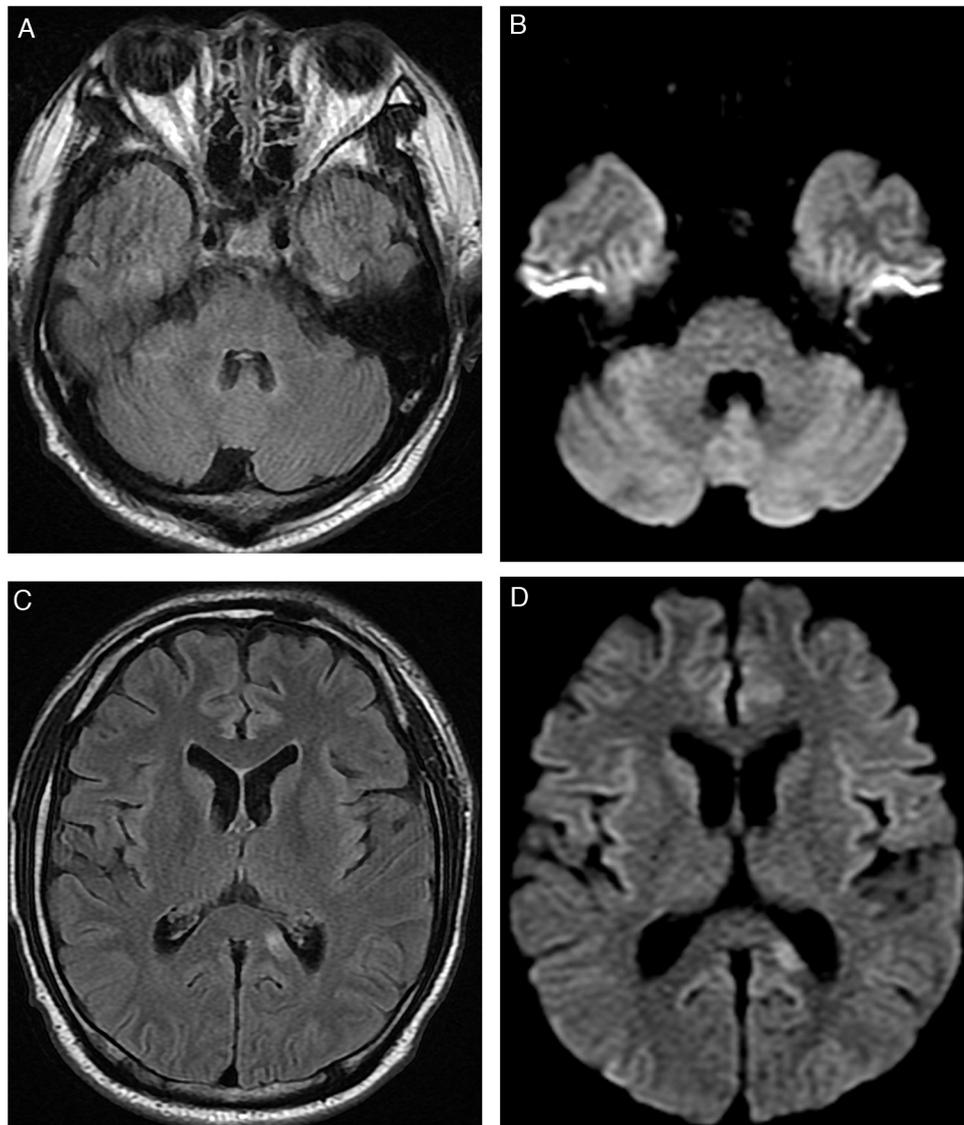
Follow-up MRI at 10 days demonstrating resolution of the dentate T2-FLAIR hyperintensity (A), with continued normal DWI (B). The corpus callosum lesion demonstrating improvement in T2-FLAIR hyperintensity (C) and decreased diffusion signal (D) with near normalization of the ADC (not shown). (FLAIR, fluid-attenuated inversion recovery; DWI, diffusion-weighted imaging; ADC, apparent diffusion coefficient).
